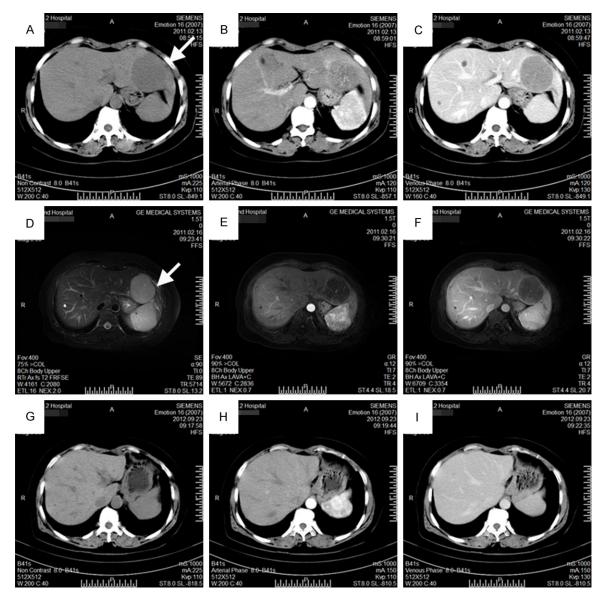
The imaging examination revealing a tumor in the II segment of the liver (white arrow). A-C. Contrastenhanced computed tomography imaging on Feb 13, 2011. D-F. Contrast-enhanced magnetic resonance imaging on Feb 16, 2011. G-I. Contrast-enhanced computed tomography imaging on Sept 23, 2012.
